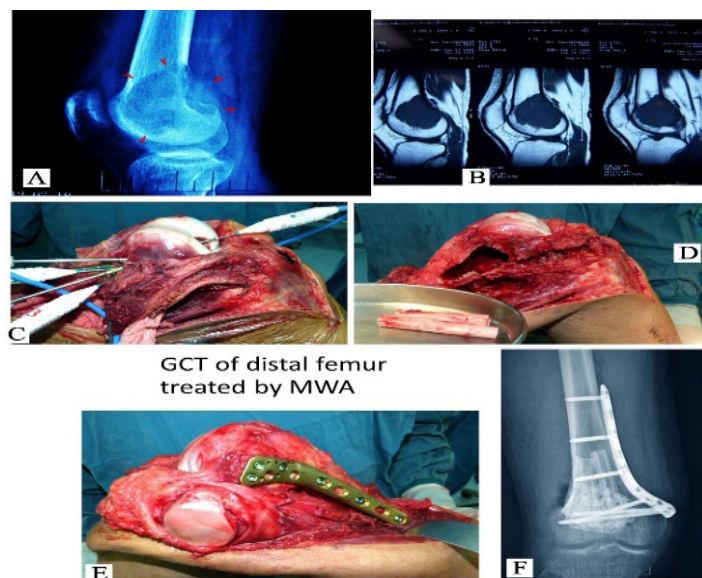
The typical Procedure of Microwave Ablation (MWA) for GCTs of the distal femur. A,B: Image data (taken at 5/9/2008) show a lytic/lucent lesions that had an epiphyseal location and grew to the articular surface. C: After complete dissection of the tumor-bearing bone from the surrounding normal tissues, thermocouples and antenna were inserted for MWA. D: Curettage (almost no bleeding during curettage after MWA.). E: Restrengthening the scaffold by fibular autograft. F: X-ray film after surgery taken. The function reached sport level after surgery 10 years.
